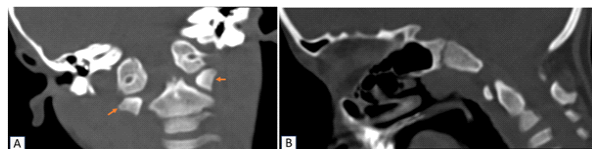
(A) CT coronal section of cervical spine with asymmetric odontoid-lateral mass interval (more on right than left) (arrow points at lateral mass of atlas on each side) (B) Sagittal CT of cervical spine shows normal anterior atlanto-dens interval (< 3 mm)
